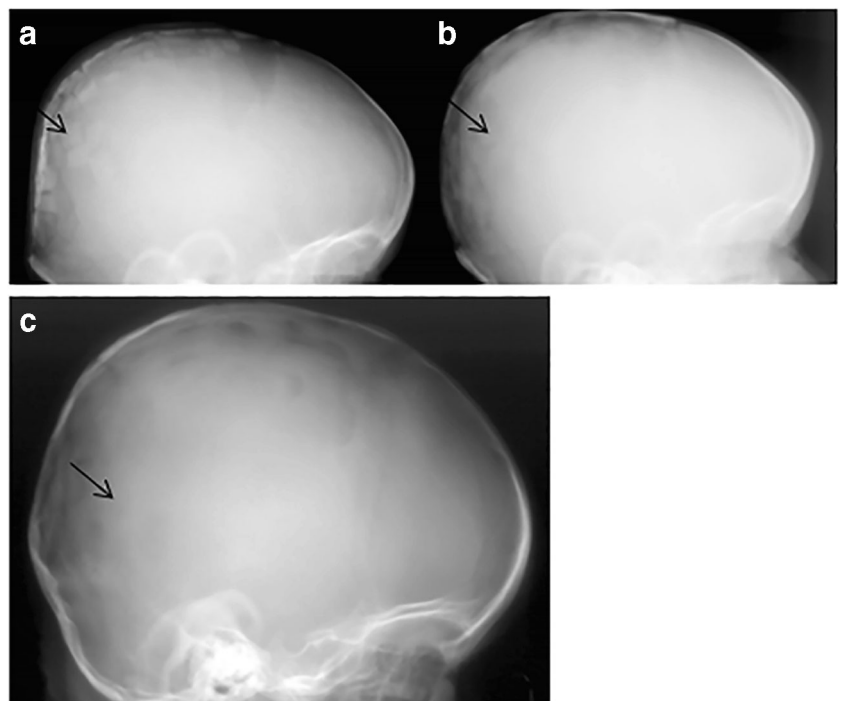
a, b Lateral skull X-rays before surgery (at 4 months) in SS and at the second early follow-up (at 24 months). Normalization of skull shape after craniectomy, no large defects after M-LC
